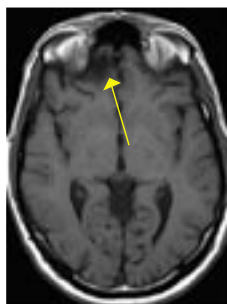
MRI Post-contrast
